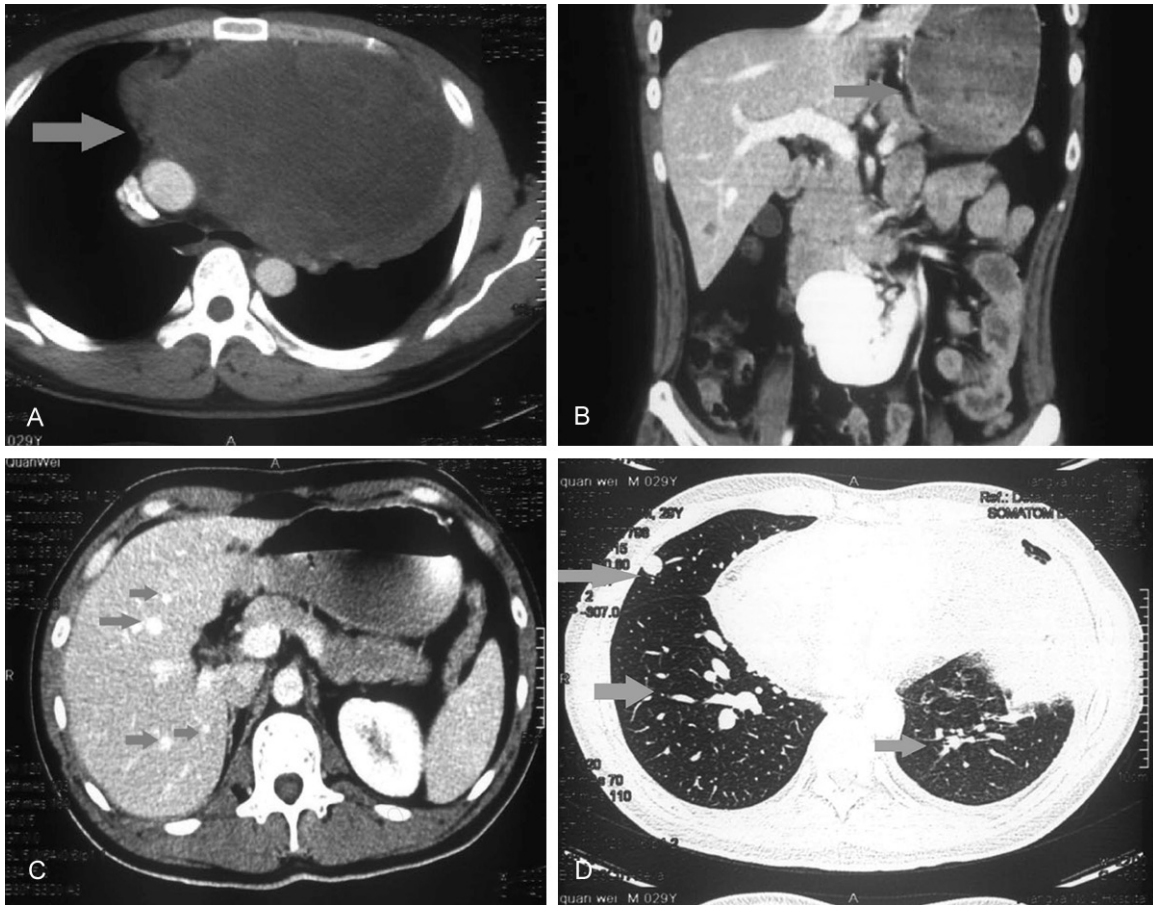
Computed tomography scan before surgery in a 28-year old man. A, B: Preoperative CT scan revealing 18 cm in diameter in the anterior mediastinum and horseshoe kidney. C: Chest CT shows multiple tumor in the bilateral lung. D: Abdominal CT reveals multiple nodular, high-density contrast mass in the liver lobe.
